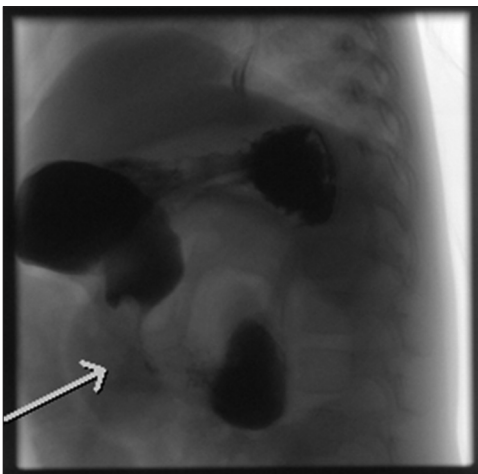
Contrast swallow radiograph
